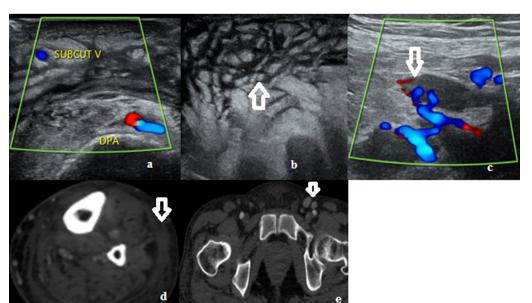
(a-c) Lower limb ultrasound and color Doppler images showing subcutaneous edema with marbled fat appearance (open arrow in b) in patient with no vascular occlusions, associated enlarged reactive inguinal lymphadenopathy showing trans-hilar vascularity (open arrow in c), this was correlated clinically as cellulitis (d) lower limb axial CT angiography (CTA) image with subcutaneous and deep fascia thickening (open arrow) in the mid leg associated with increased girth (e) lower limbs axial CT angiography (CTA) image at the level of the groin showing reactive lymph glands enlargement (open arrow).
